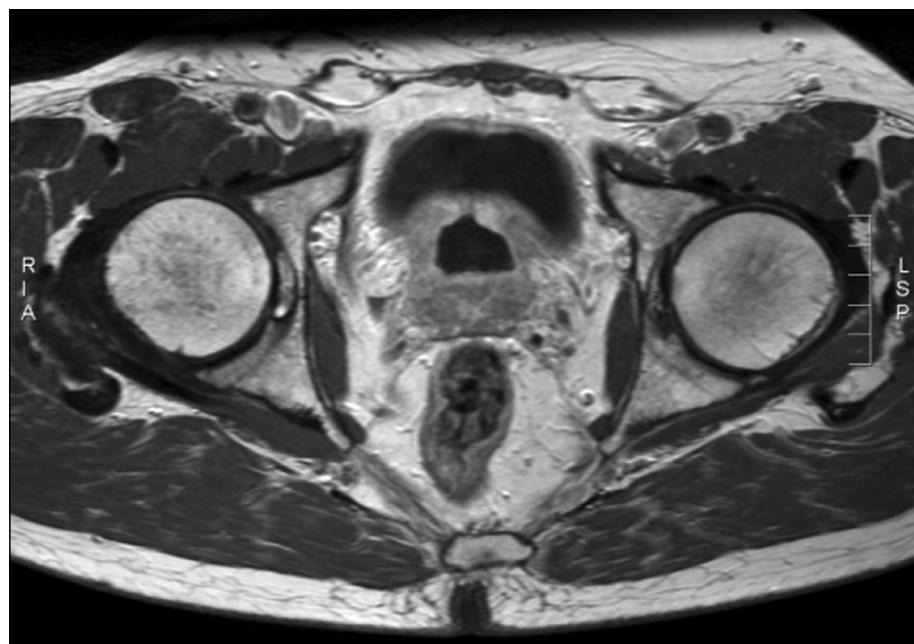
Magnetic resonance imaging after transurethral resection of the prostate not showing further tumor.
